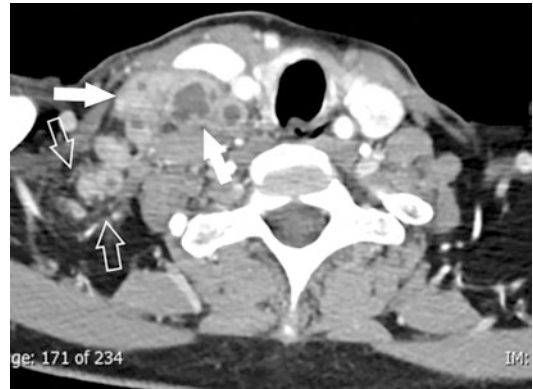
Matted lymph nodes with peri-adenitis in tuberculous lymphadenitis. Axial contrast-enhanced CT image shows matted necrotic cervical lymphadenopathy (arrows) with perinodal fat stranding (open arrows)
